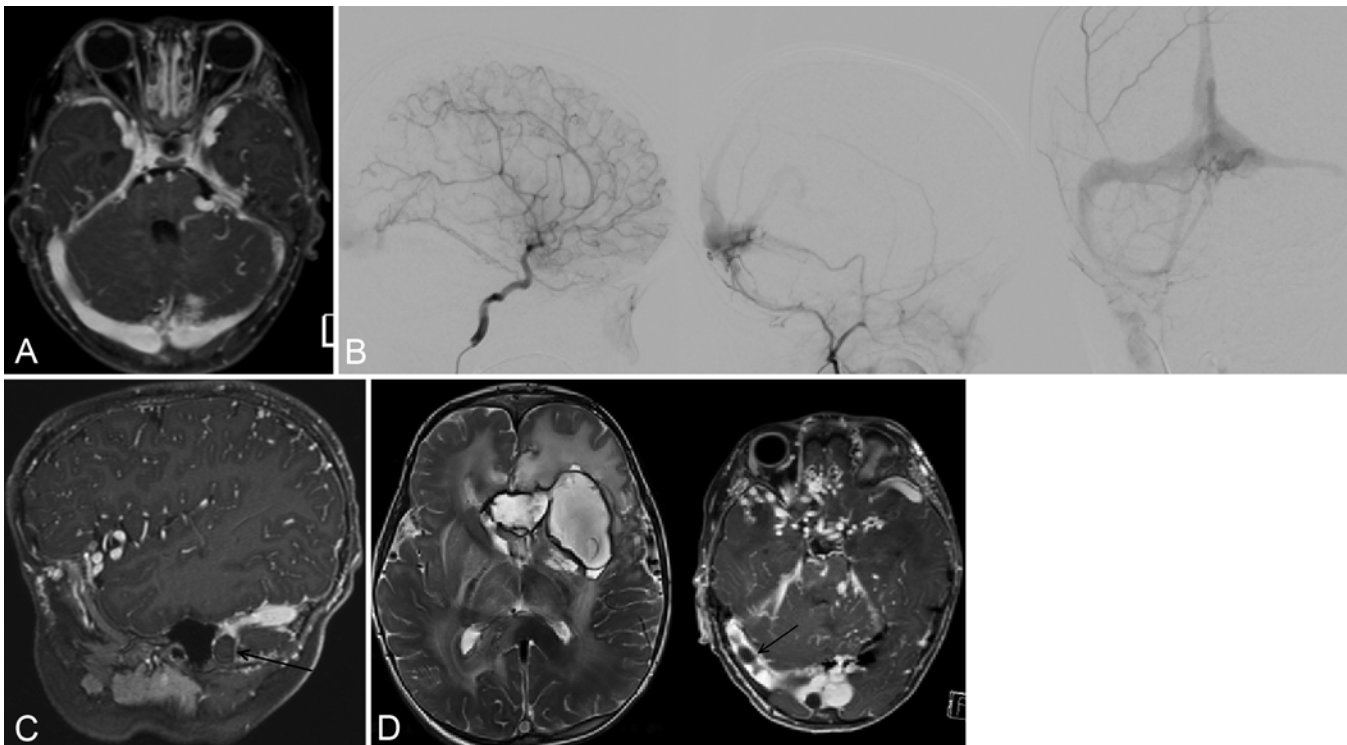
Case 3. A: Axial T1-weighted postcontrast MR image showing a dAVM in the left posterior fossa, adjacent to the torcular herophili. Dilated cortical veins are noted. B: Angiograms of the right ICA (*left*) and right ECA (*center*) show a dAVM nidus fed by branches of the right ICA and ECA. Anteroposterior view of a right ECA angiogram (*right*) demonstrates retrograde flow and narrowing of the left sigmoid sinus. C: Sagittal T1-weighted postcontrast MR image shows occlusive thrombosis of the right sigmoid sinus (*arrow*). D: Axial T2-weighted MR image (*left*) shows a large intraparenchymal hemorrhage associated with cerebral edema in the bilateral frontal lobes and basal ganglia. An axial T1-weighted postcontrast MR image (*right*) shows extension of the right transverse sinus thrombosis (*arrow*).
